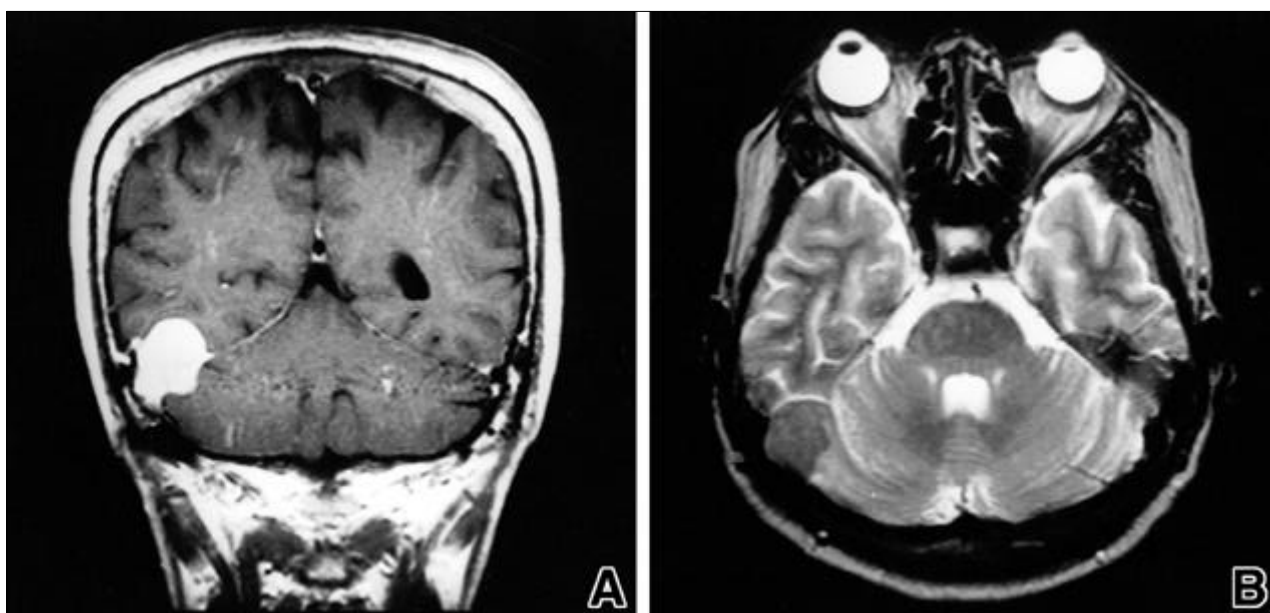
A, Preoperative Gd-DTPA contrast enhanced T1-weighted coronal image shows homogeneously enhanced lobulated mass encroaching the transverse dural sinus with characteristic dural reaction along the tentorium and sinus dural wall. B, T2-weighted axial image shows well-marginated extraaxial mass which has iso-signal intensity to gray matter.
